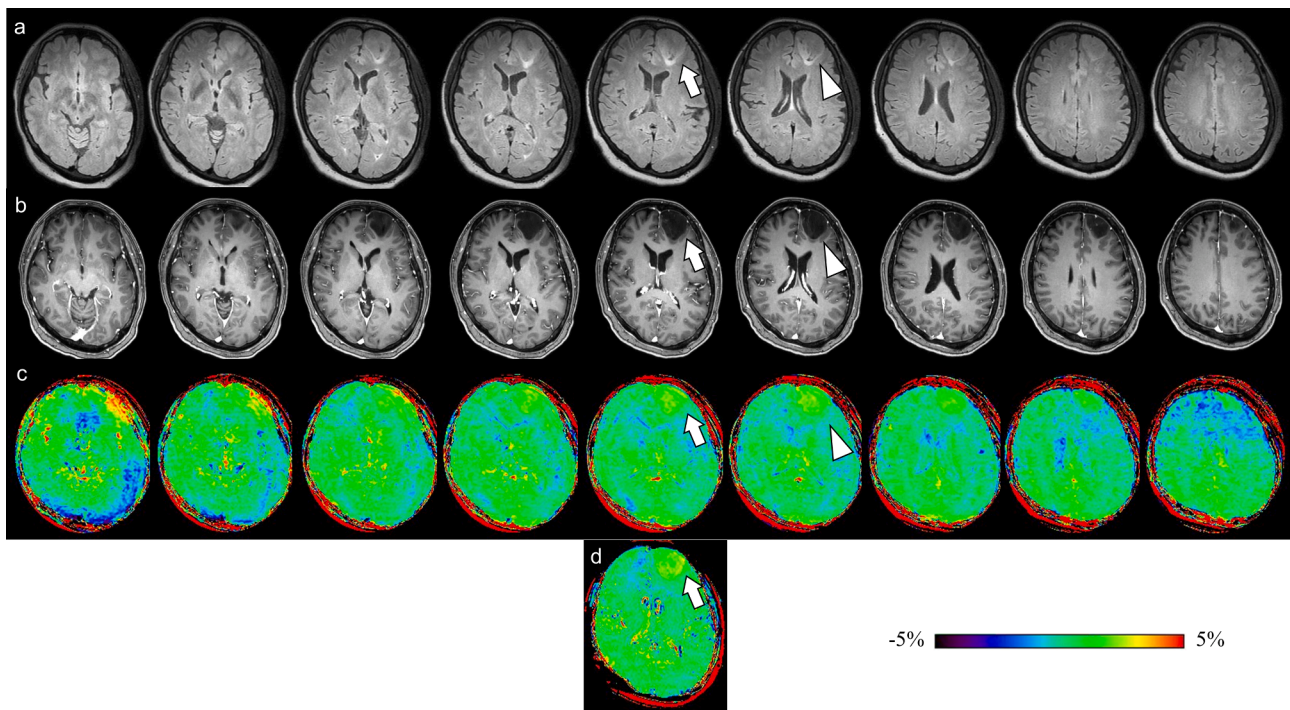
Astrocytoma, IDH-mutant, CNS WHO grade 2 in a 50-year-old female. (a) FLAIR, (b) Gd T1WI, (c) 3D MTRasym at 3.5 ppm, and (d) 2D MTRasym at 3.5 ppm. The MTRasym values at 3.5 ppm for the 2D (arrow), 3D_{all}, and 3D_{max} (arrowhead) methods were 1.85 ± 0.49 , 1.55 ± 1.10 , and 1.85 ± 0.82 , respectively. Both the 2D MTRasym at 3.5 ppm (d) and the 3D MTRasym at 3.5 ppm (c) showed a mild increase in the signal intensity in lesions with high signal intensity on FLAIR imaging (a). Similar signal intensities in multi-slices of the 3D MTRasym at 3.5 ppm (c) were observed in high-signal lesions on the FLAIR images (a).
